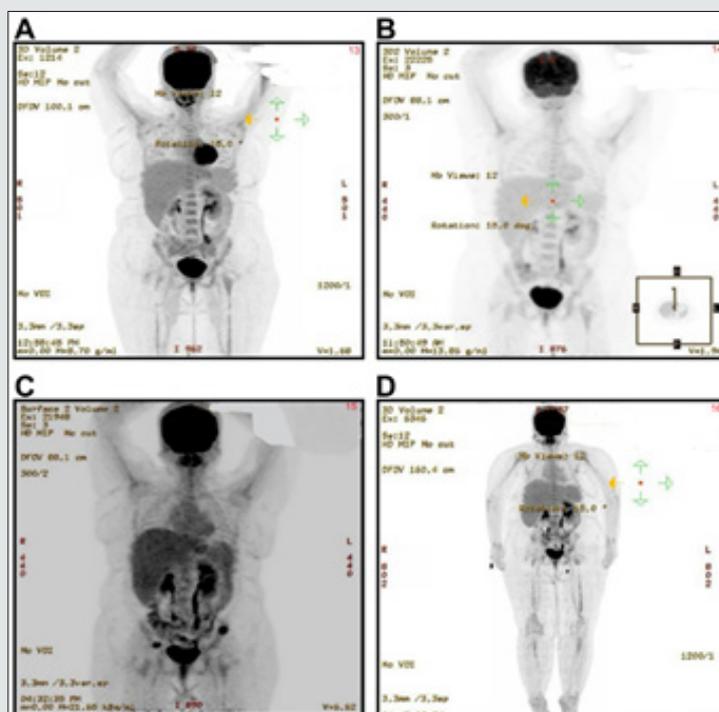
(A): Focal uptake (SUVmax 1.3) in the right anterior third and left anterior eight ribs of the patient in Case 3. (B): No evidence of FDG uptake suggestive of a complete response. (C): New lytic lesions involving the left iliac region and the right acetabulum. (D): No evidence of FDG-avid lesions, in keeping with disease remission.
